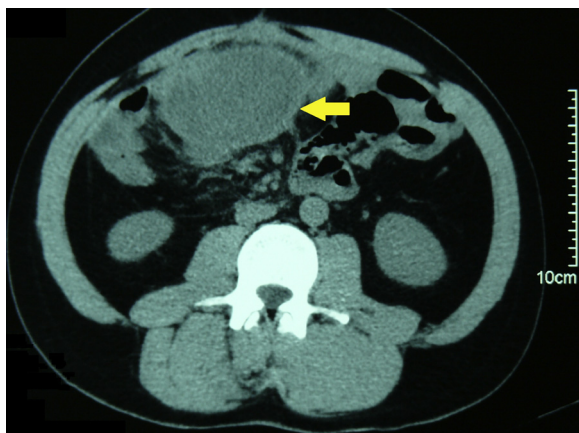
Abdominal computed tomography showed a large mesenteric mass, extending 13 cm from the epigastrium to L3, with internal massive liquefaction.
